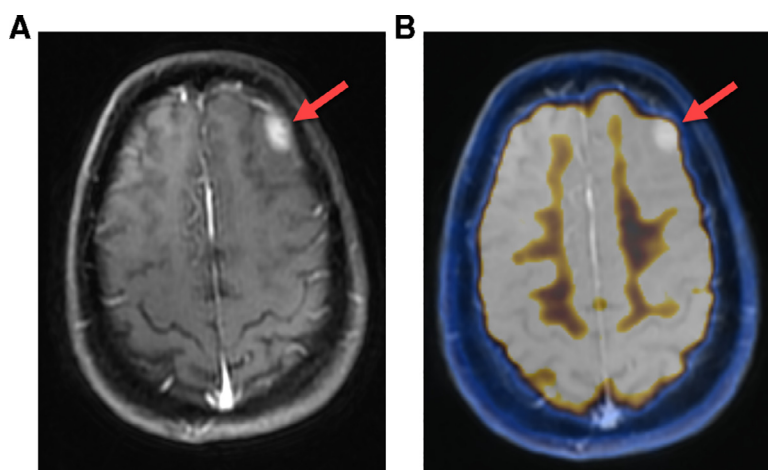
Incidental dural metastasis identified on a whole-body PET/MR scan. While the lesion (arrow) is well seen on the axial contrast-enhanced T1-weighted fat-suppressed MR image (A, LAVA-flex), it is not as easily appreciated on the fused PET/MR image (B, arrow) because its uptake is within the range of normal cortex. Acquisition of this MR pulse sequence takes only approximately 2:30 minutes for the whole body.
